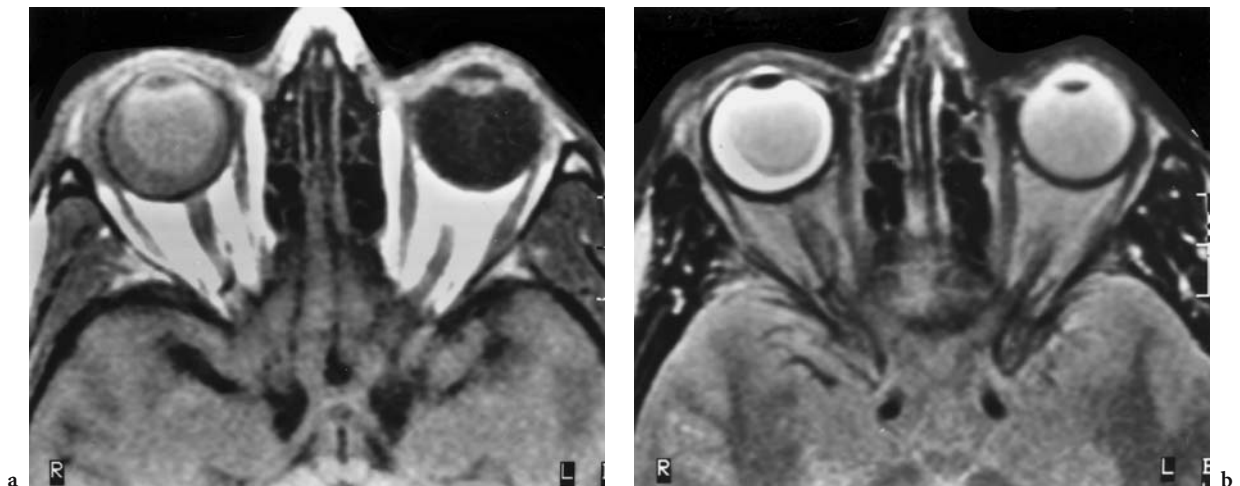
A 35-year-old man with acute visual loss of the right eye associated with known Behçet disease. Diagnosis: spontaneous vitreous body hemorrhage of the right globe and ipsilateral subchoroidal effusion. MRI: a Axial T1-weighted native view with subacute hemorrhage of the right vitreous body indicated by slight signal enhancement compared with the left globe. In addition, a comparison with the normal signal of the left globe indicates the presence of effusion characterized by signal diminution at the posterior part of the globe. b Corresponding T2-weighted, proton density image with demarcation of the fluid by signal enhancement of the proton-containing fluid (T2-time prolongation). At that time of examination, the signal of the right vitreous body appeared similar to the left one due to the fact that the isointense subacute hemorrhage of the vitreous body did not yet contain methemoglobin. The diagnosis of vitreous hemorrhage can only be made based on a comparison with the T1-weighted image. (From MÜLLER-FORELL and LIEB 1995)
